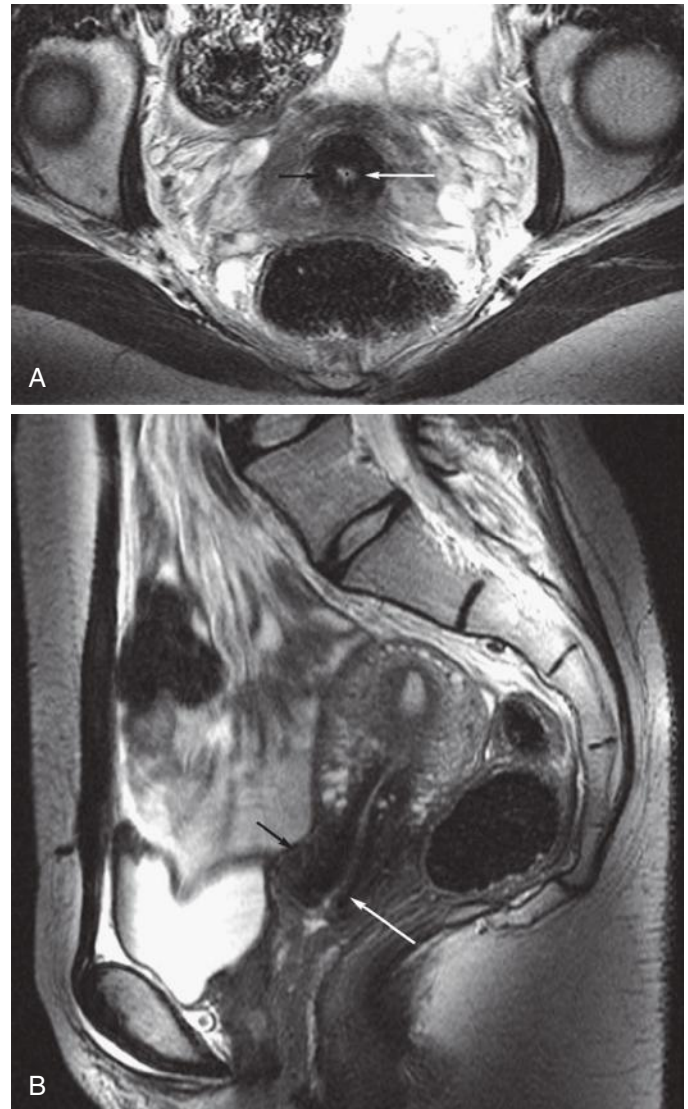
Normal cervix. Axial (A) and sagittal (B) T2-weighted images demonstrating the normal zonal anatomy of the cervix, composed of an outer rim of smooth muscle (*short black arrow* on A and B) of intermediate signal intensity, a dark low signal intensity ring of fibrous stroma (*long white arrow* on A and B), and the high signal intensity endocervical mucosa (*asterisk* on A).
